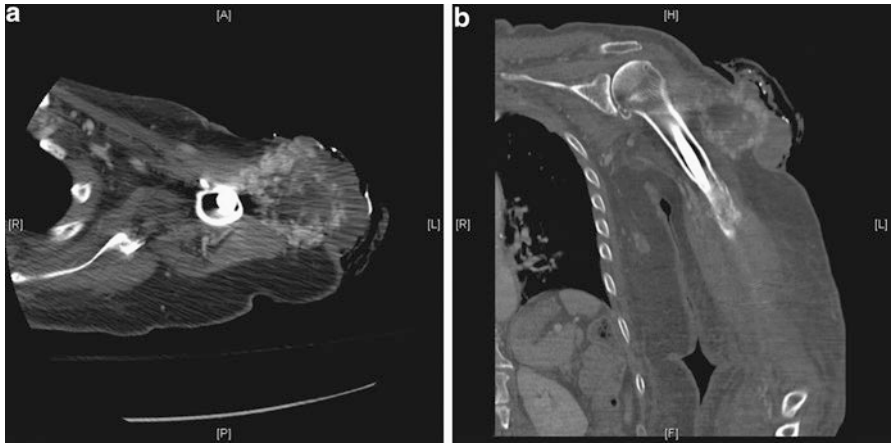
CT images (a, b) of angiosarcoma of the humerus causing pathological fracture (s/p fixation) with demonstration of soft tissue metastases affecting the left upper extremity soft tissues
